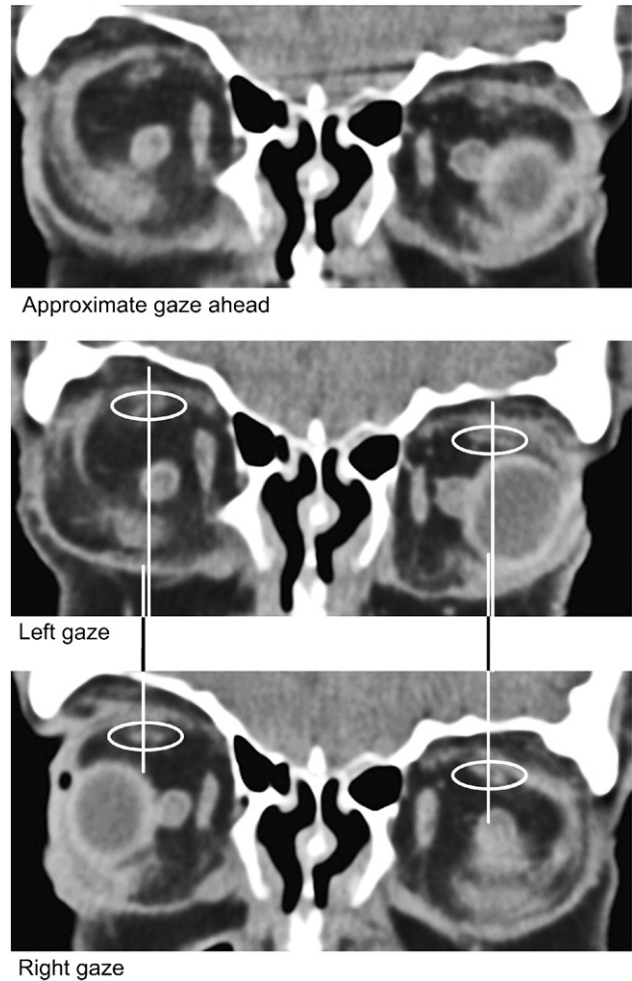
CT scans in three positions of gaze of the patient with Crouzon's syndrome. Little displacement of the bellies of the superior and inferior rectus muscles occurred in left as compared to right gaze, despite the absence of the bony orbital wall. Note the conspicuous intermuscular membrane.
